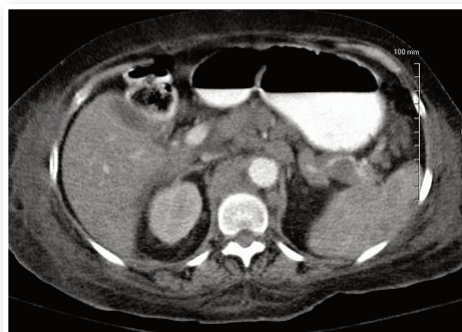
This computed tomography scan of the abdomen shows worsening of the lymphadenopathy with mass effect and compression of the intra-abdominal inferior vena cava.
